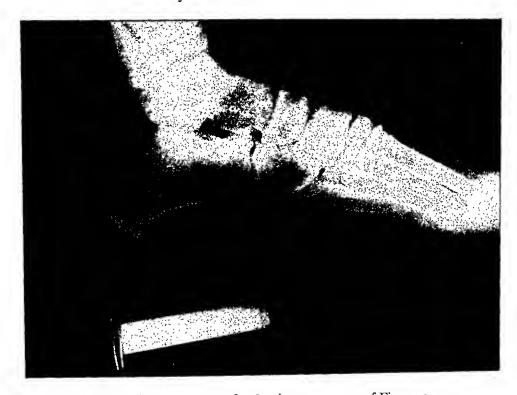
Roentgenogram for densitometer trace of Figure 5.
